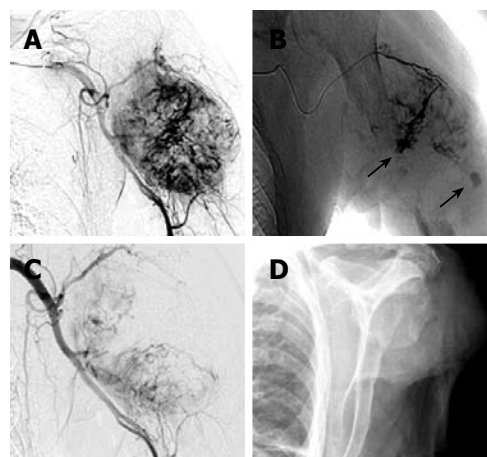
Catheter angiography of the tumor before (A, B) and after embolization (C), X-Ray after final treatment with amputation of the left upper extremity (D). A: Catheter angiography of the axillary artery reveal a round hypervascular tumor; B: Selective angiography of a tumor feeding vessel as side of application of Bead Block (size 300-500 μ m, Terumo Europe, Leuven, Belgium) for embolization; C: After embolization of main parts of the tumor, at this status no areas of bleeding detectable but small parts of the tumor still perfused; D: Final treatment with amputation of the left upper extremity.
